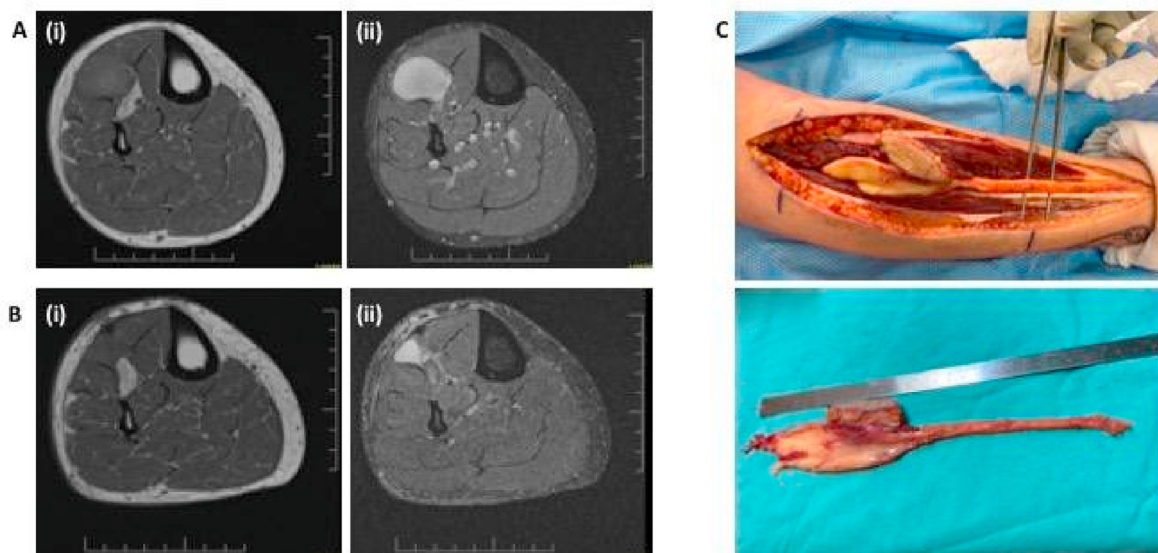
Representative case of intermuscular myxoid liposarcoma located in the plane between the tibialis anterior and flexor hallucis longus muscle bellies. Shown are representative T1-weighted (i) and STIR (ii) MRI cuts from scans taken pre- (A) and post-radiotherapy with 50 Gy (B). The tumour shrank with radiotherapy from a pre-radiotherapy ellipsoid tumour volume of 107.4 cm³ to a post-radiotherapy ellipsoid tumour volume of 7.4 cm³ for a % change of -93.1%. The tumour was marginally excised with minimal muscle resected as a margin except in the region of the open biopsy (C). Superior, medial, lateral, anterior, and posterior margins were <1 mm and the patient was classified as having multiple <1 mm margins. The patient is alive with no evidence of disease 13 months post-surgery.
